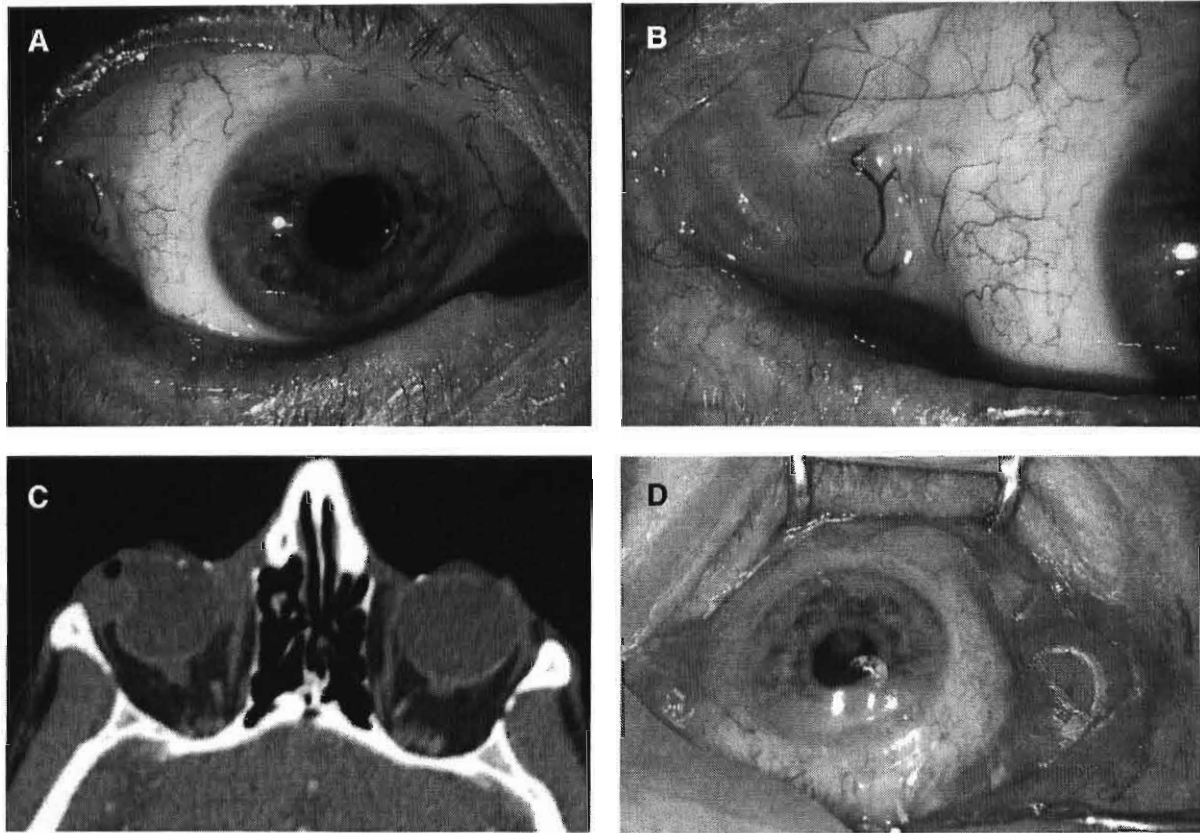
Case 1. An 82-year-old man had an orbital mass that proved to be a swollen MIRAgel scleral buckle used for retinal detachment repair 15 years earlier. A, Mass was palpable through the temporal eyelid; deep conjunctival involvement was noted. B, Close-up view of mass reveals translucent material underlying white, fibrous Tenon capsule and prominent vessels. Note that the eye is pushed 10 mm nasally by the mass. This appearance is similar to a large orbital inclusion cyst. C, CT shows temporal mass indenting the globe with dense temporal portion and more lucent medial portion. Much smaller nasal portion of scleral buckle is noted at nasal equator of the eye. D, At surgery, the mass proved to be a swollen MIRAgel implant that had buckled on itself.
